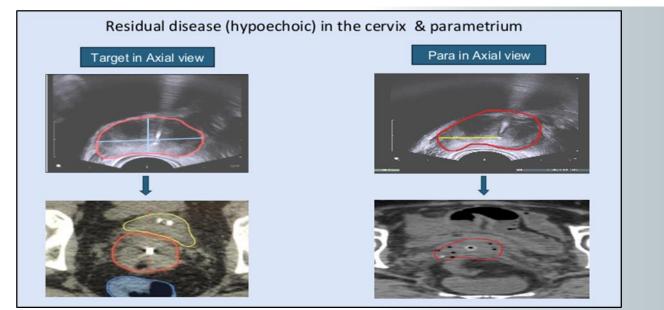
Using target width and thickness measurements from TRUS images to contour on CT images
